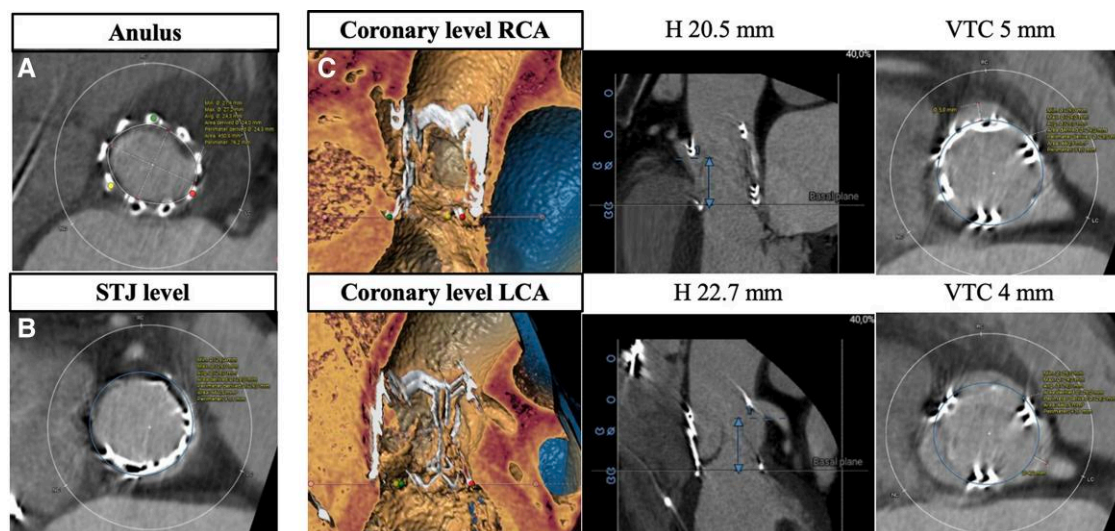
Multi-detector computed tomography study. (A) Measurements of the annulus of the surgical aortic valve; (B) measurements of sino tubular junction and its relationship with sutureless bioprosthesis valve; (C–H) 3D rendering of sutureless bioprosthesis valve and both coronary arteries with an estimation of coronary height (H) from the annulus level and virtual transcatheter heart valve-to-coronary ostium distance. RCA, right coronary artery; LCA, left coronary artery; H, coronary height; VTC, virtual transcatheter heart valve-to-coronary ostium distance.
